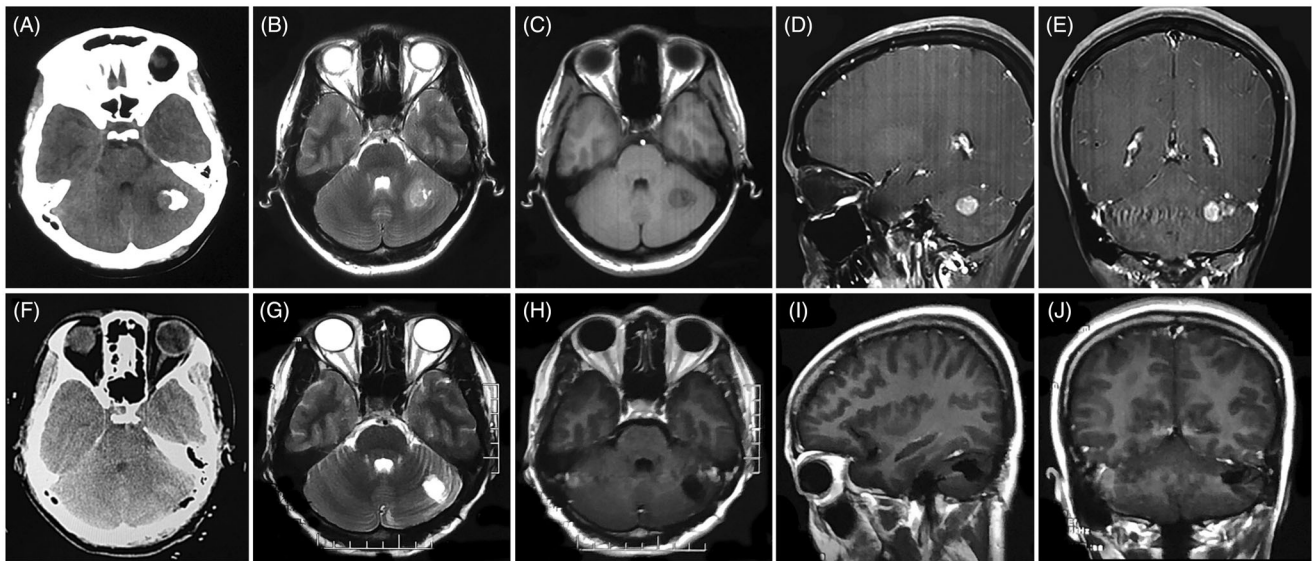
Intraparenchymal meningioma located in the left cerebellar hemisphere. Preoperative CT (A) showed revealed an iso-to hyperdense lesion in the left cerebellar intraparenchyma, 2.7×2.3 cm in size with peripheral calcification. MRI demonstrated (B–E) the mass lesion was low-in-tense on T1-weighted and high-in-tense on T2-weighted, with homogeneous enhancement. No dural tail sign was noted. Postoperative CT (F) and MRI (G–J) showed that the tumor was completely removed.
